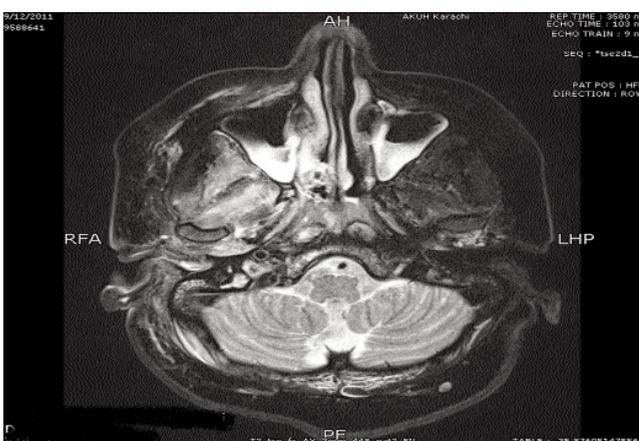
Axial section of T2 weighted MRI-scan showing oedematous non-patent right external auditory canal.
